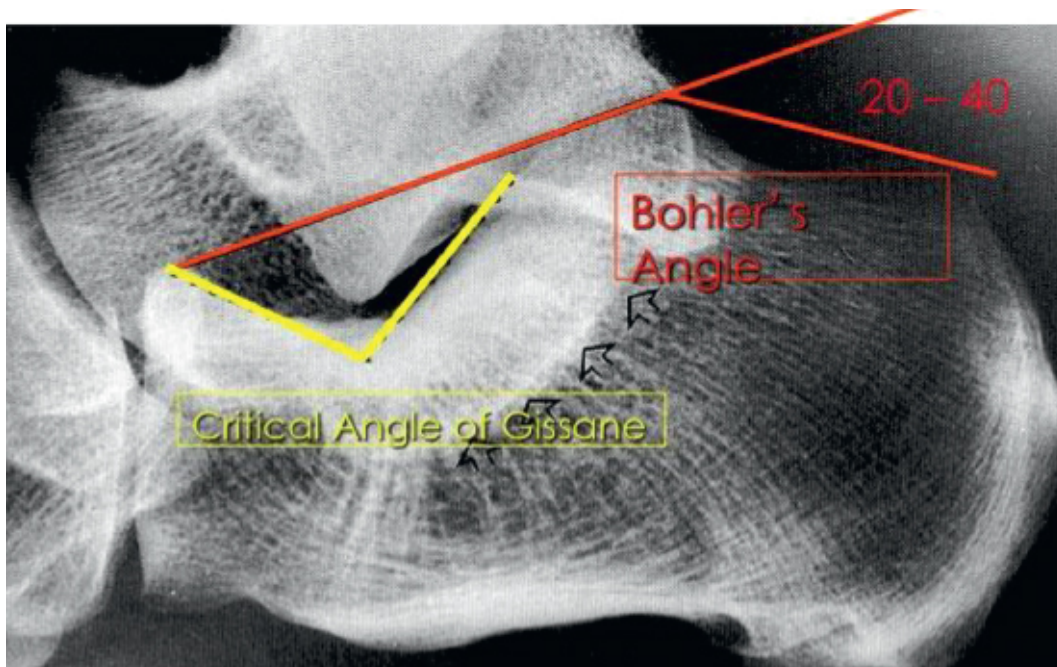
Calcaneus lateral x-ray.
